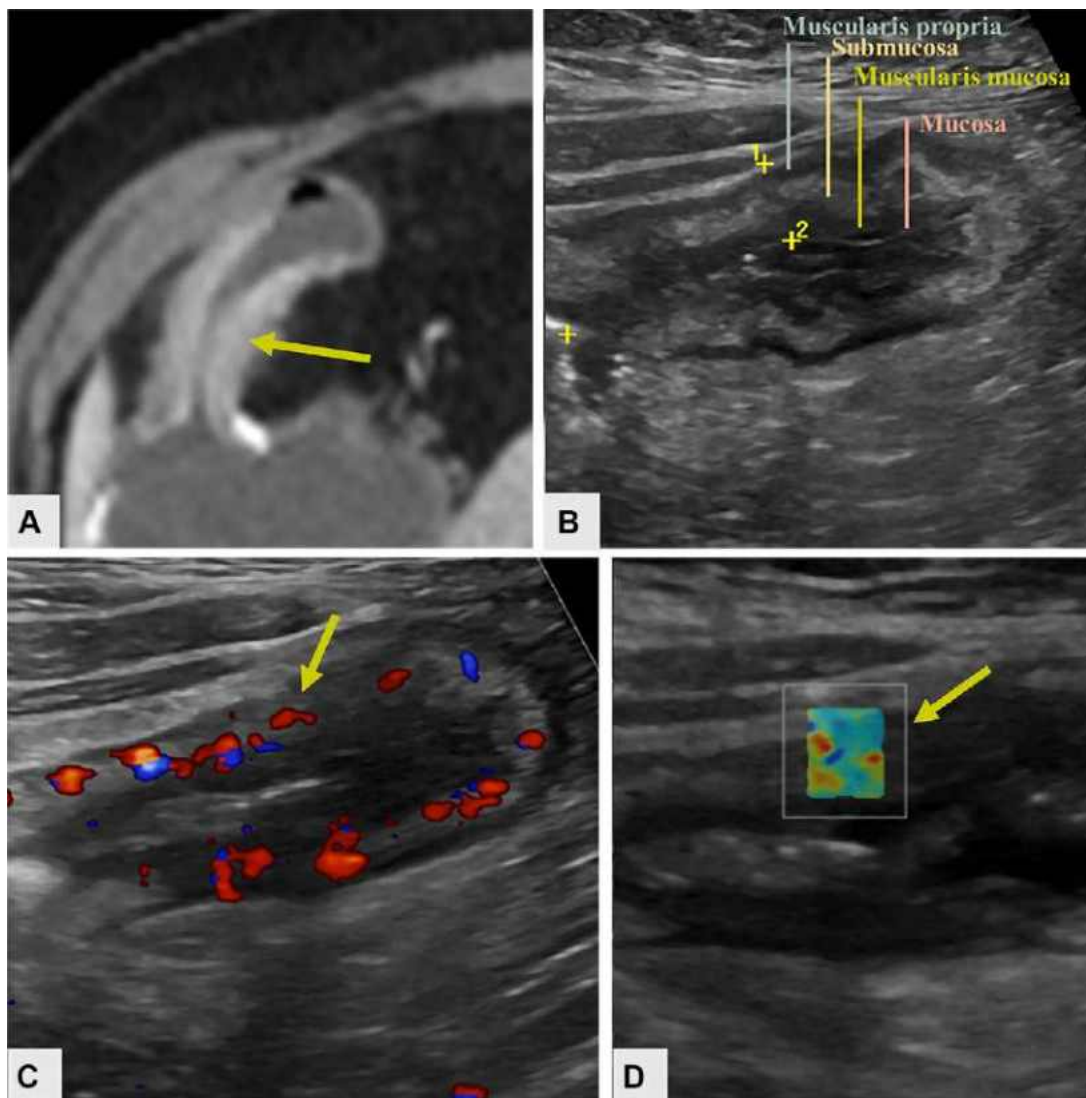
Short-segment stricture with inflammation involving the neoterminal ileum in a 42-year-old woman with prior ileocecal resection. (A) Axial contrast-enhanced CT image shows a 5-cm long stricture (arrow) with inflammation in the distal neoterminal ileum, which is characterized by 9-mm wall thickening, mural enhancement, and luminal narrowing. (B) Longitudinal gray-scale US image shows bowel wall thickening with mainly an expanding submucosal layer. (C, D) Additional longitudinal images with color Doppler US (C) and shear-wave elastography (D) show enhanced vascularity (arrow in C) and increased stiffness of the involved segment (arrow, inset in D), respectively.
